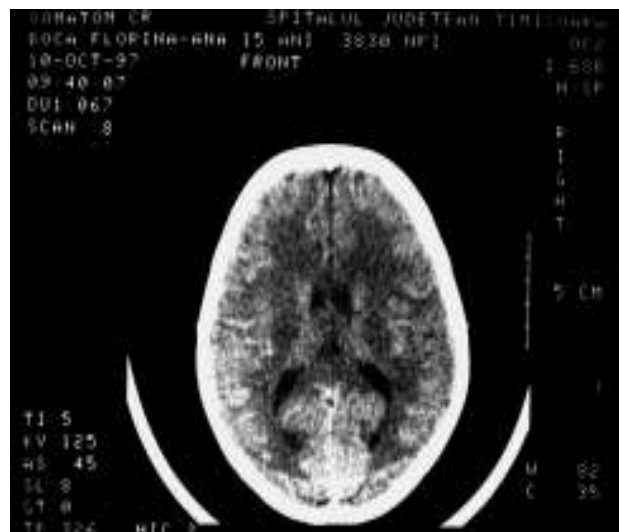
Native cerebral CT exam that revealed normal aspects.
